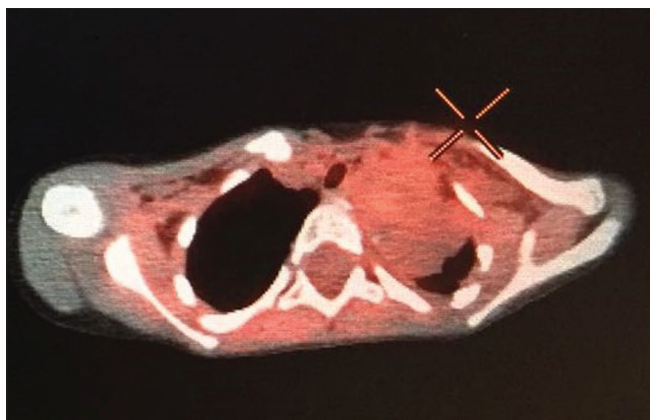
Positron emission tomography/computed tomography imaging of neurofibroma in mediastinum and axilla
